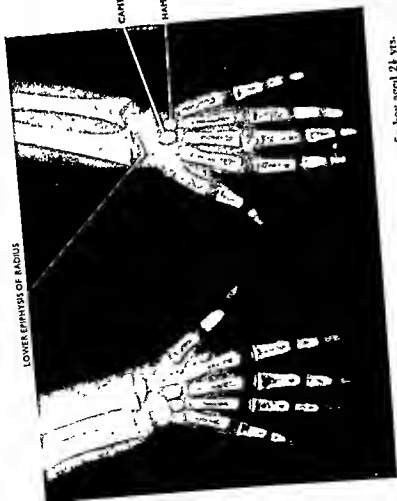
The radiograph of hand and lower forearm of a boy aged 2 1/2 yrs.
